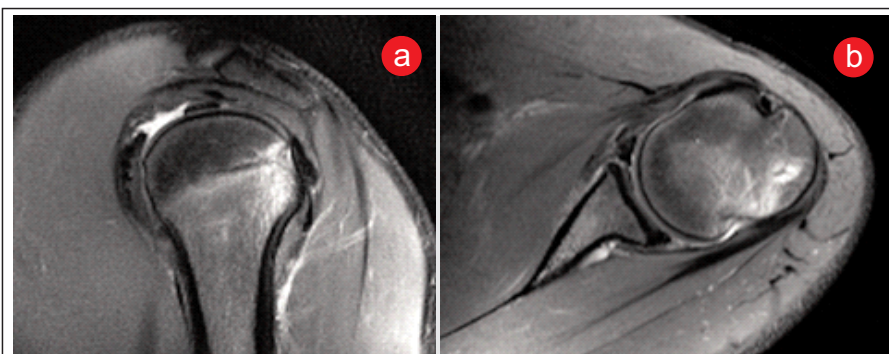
(a & b) Magnetic resonance images of Hill–Sachs lesion.
